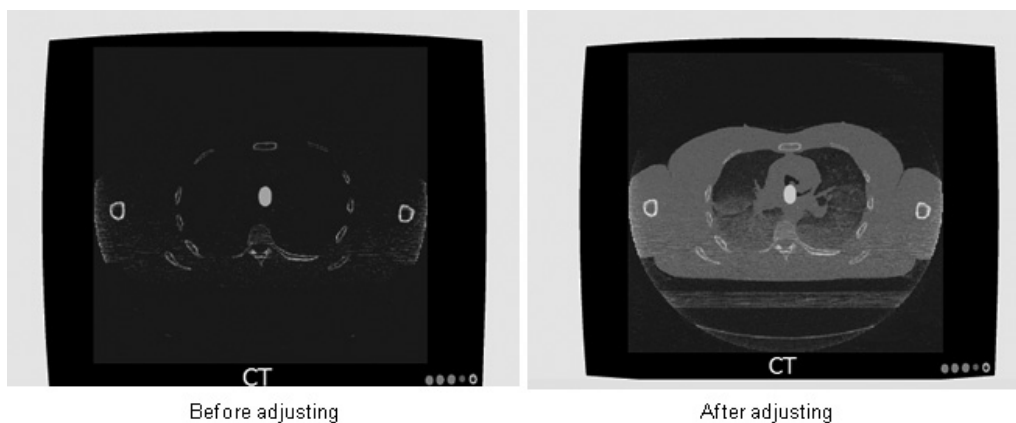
A real-time CT imaging window that can be zoomed into any region by adjusting display window.
